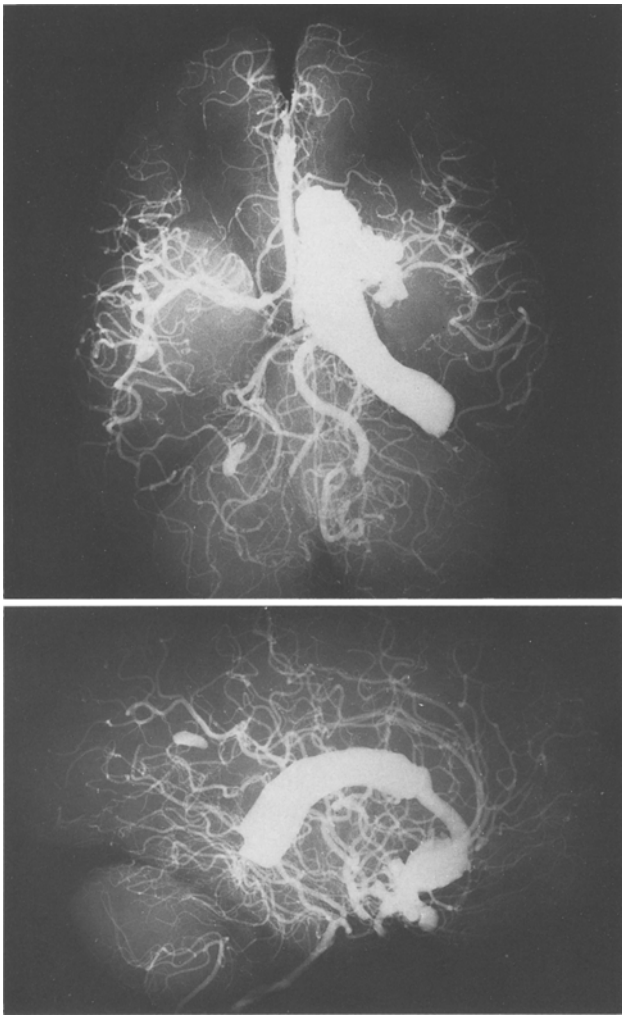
Intraventricular haemorrhage from rupture of aneurysm of the right middle cerebral artery. Haemorrhage extending into posterior horn of right lateral ventricle (*top*). Lateral X-ray from separated brain (*bottom*)
